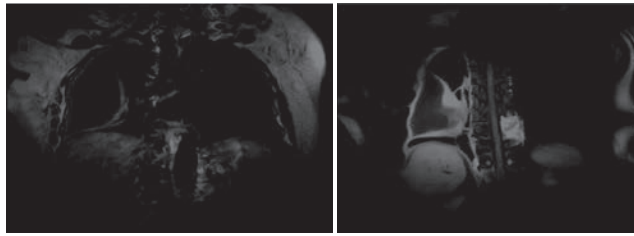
MRI thoracic vertebra.
